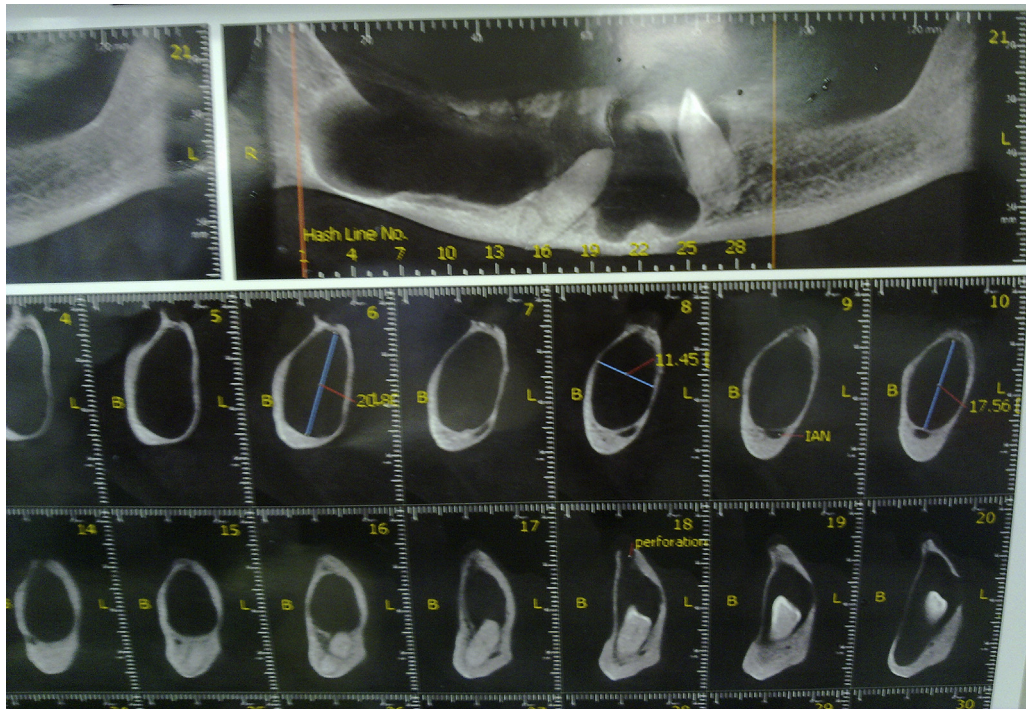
Cone-beam computed tomogram of a large glandular odontogenic cyst.
